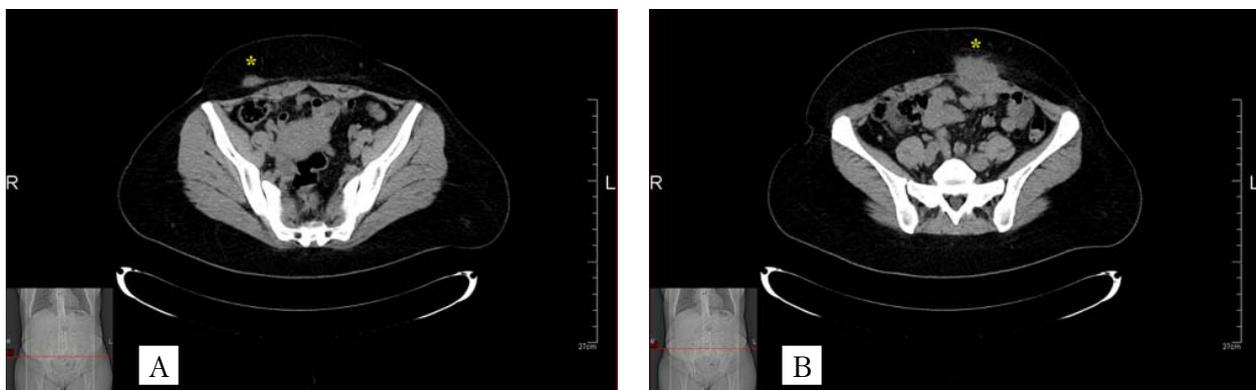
Axial computed tomography: solid mass in the subcutaneous tissue of the right iliac region (A); solid mass of the left iliac region, involving the subcutaneous tissue, fascia, and left rectus abdominis muscle (B)
